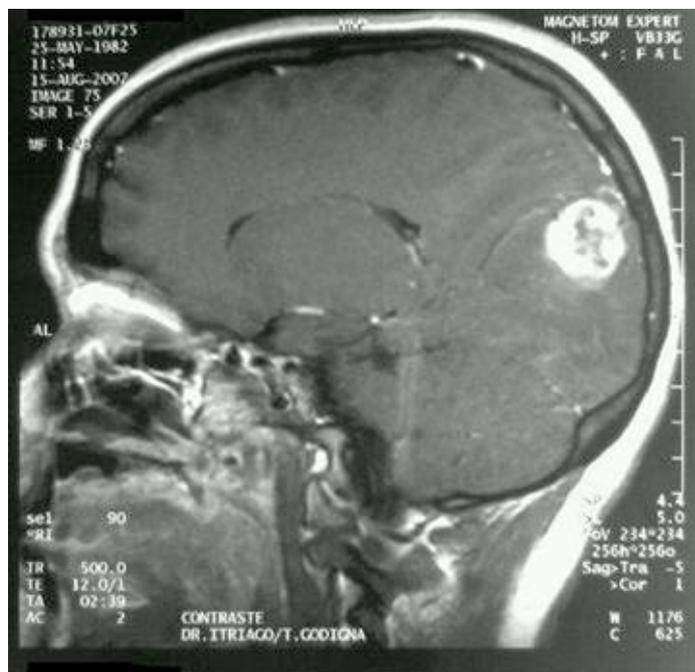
2. MRI using contrast with Gadolinium shows: Metastasis of choriocarcinoma in left parietal posterior region, oedema produces a mass effect in the left occipital horn.
